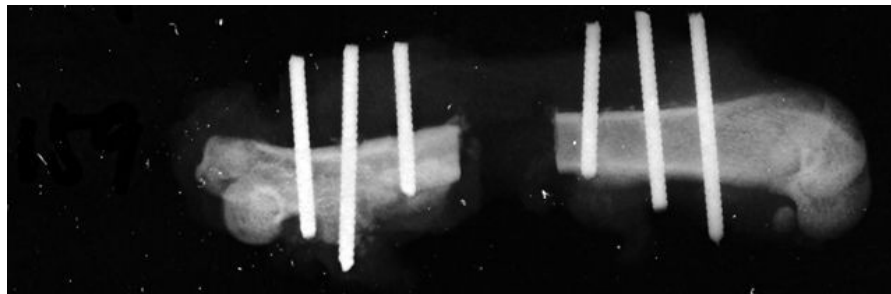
Radiograph of femur with defect at 1 week after contamination with 10^4 CFUs of *S. aureus* and 10^8 CFUs of *A. baumannii* from the bone isolate (note the sites of lysis)
